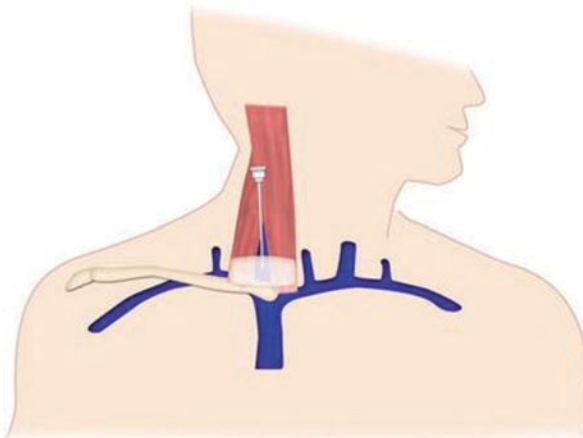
Site of puncture for right internal jugular approach. Identify the two heads of the sternocleidomastoid muscle and place the ultrasound probe just above the level of the clavicle. Identify the internal jugular vein on the ultrasound screen and adjust the probe such that the vein is in the center of the screen. The needle is then inserted at the midpoint on the superior border of the ultrasound probe
